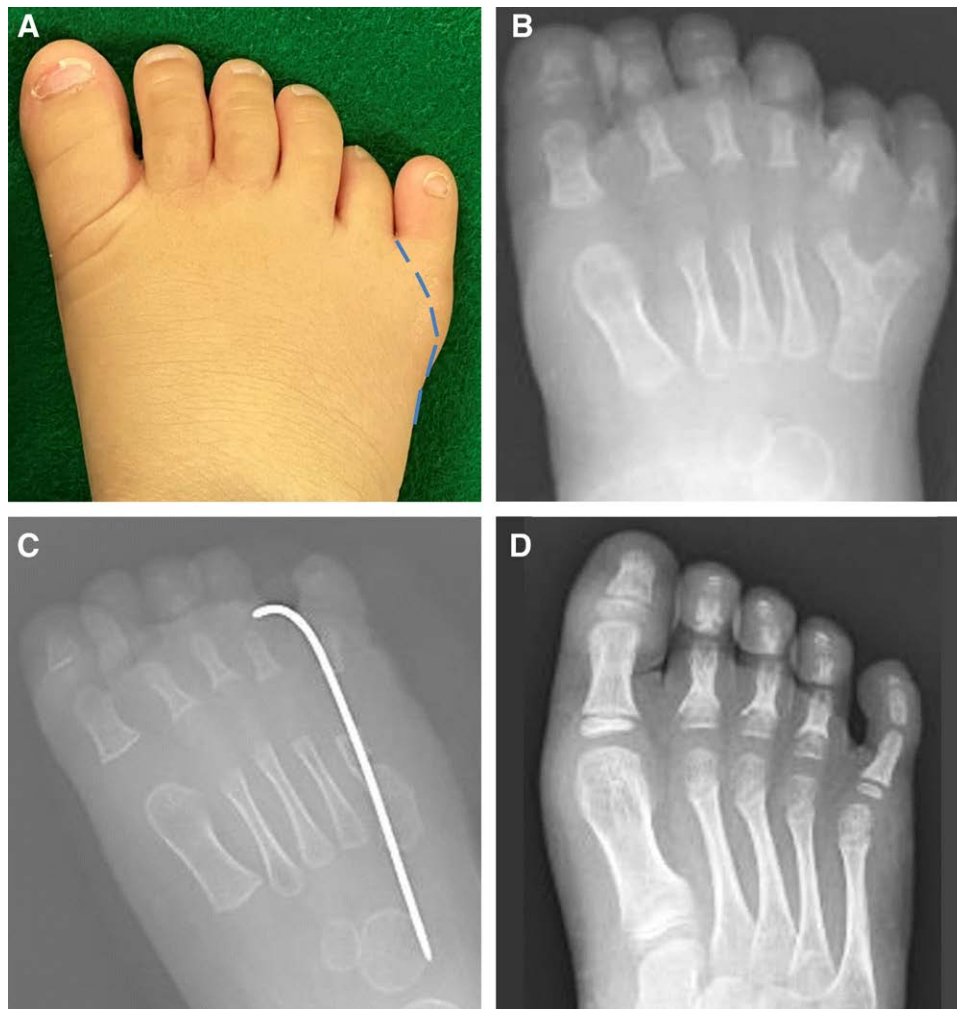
Representation of a type A-M foot. A, Preoperative appearance. The dotted lines indicate a spindle-shaped skin incision. B, The type A-M foot exhibited Y-shaped metatarsal bifurcation. C, Surgical excision of the sixth toe and corrective metatarsal osteotomy were performed. D, Five years postsurgery, the x-ray revealed favorable alignment of the fifth metatarsal.
